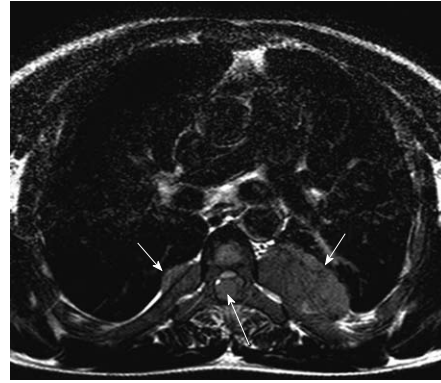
Preoperative axial magnetic resonance imaging, T2 weighted, shows paravertebral and intracanal masses, isointense with the spinal cord, widening the ribs (short arrows) and causing cord compression (long arrow).
